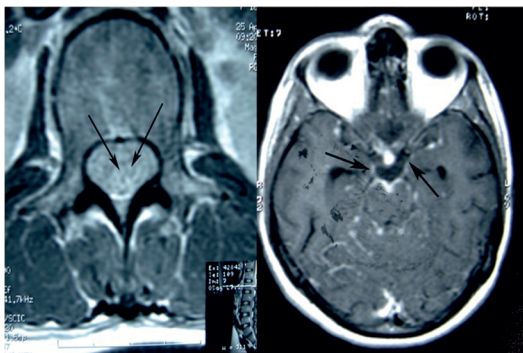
Contrast-enhanced axial T1 weighted lumbar spine MRI shows extensive shaggy enhancement of the arachnoid, nerve roots, and conus medullaris.
